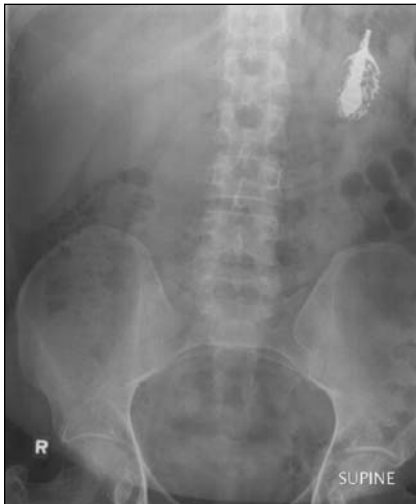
Abdominal radiograph showing the retained foreign object in the stomach 2 months after ingestion.
